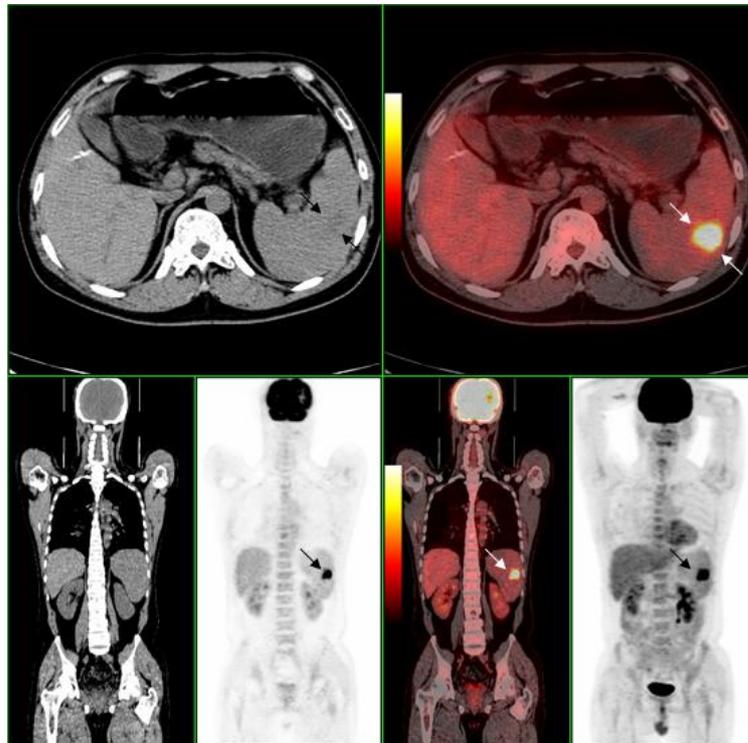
Restage IIIS NHL of a 34-y-old man, who was previously diagnosed as B cell NHL. The axial and coronal PET/CT images show ^{18}F -FDG-avid splenic mass (black and white arrows, S/L ratio = 6.8), proven to be remain NHL on biopsy, with absence of other ^{18}F -FDG-avid disease in the whole body after six cycles of chemotherapy.
